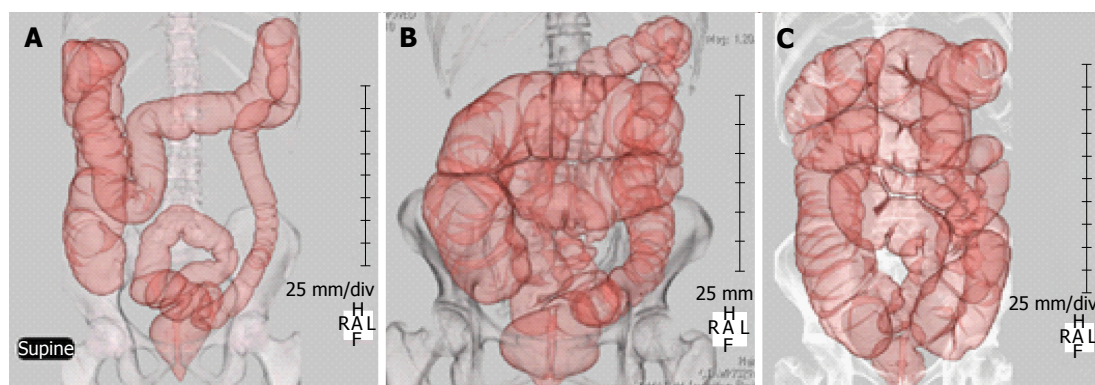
Computed tomography colonography. A: Typical diarrhea type IBS; B: Typical constipation type IBS; C: Typical functional constipation; IBS: Irritable bowel syndrome.
